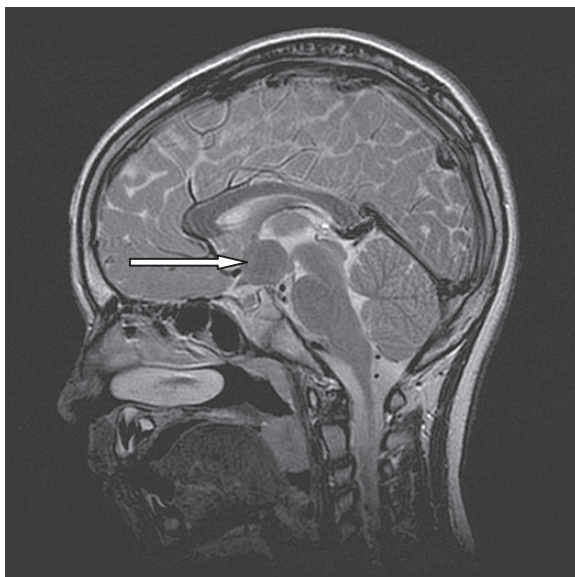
Sagittal view of T2-weighted magnetic-resonance scan of a $2.1 \times 2.3 \times 1.8$ cm mass centered in the hypothalamus
